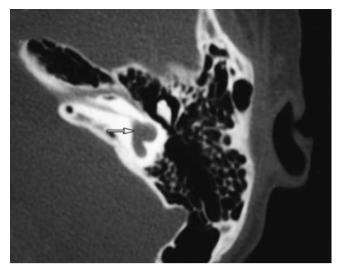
Common cavity malformation (arrow) CT scan
